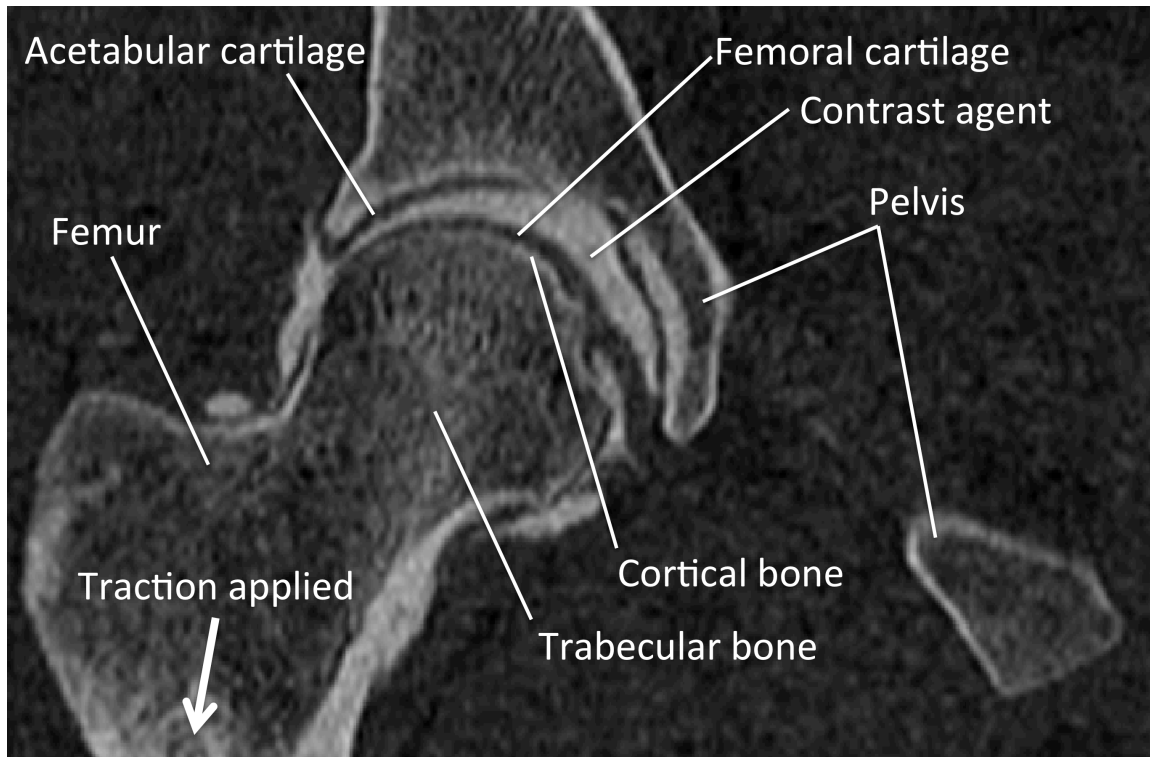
CT image used for bone and cartilage geometry definition, showing traction with contrast agent injected for cartilage surface distinction. Sagittal scan from CT scans available from University of Utah Musculoskeletal Research Laboratories [68].
